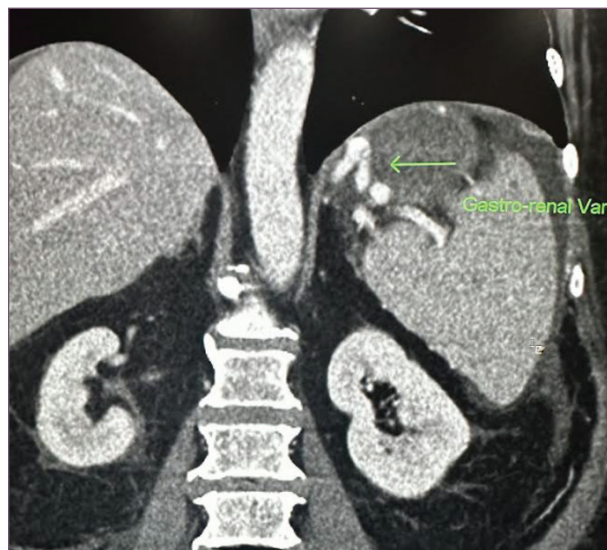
Coronal slice CTA image demonstrating the large left renal gastric varix (green arrow).
